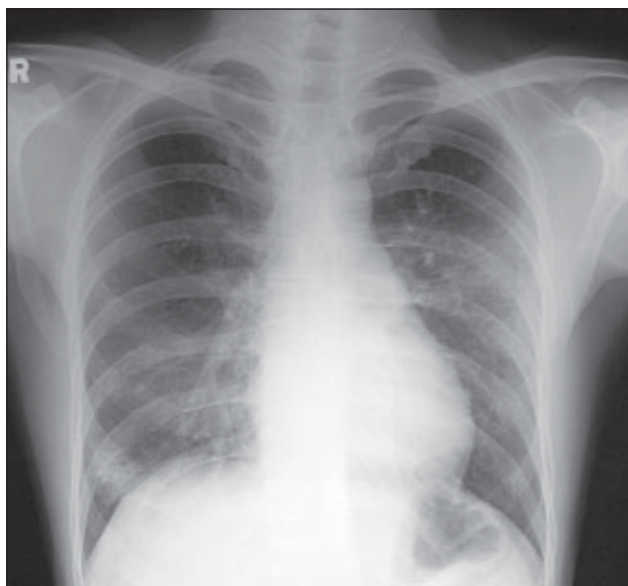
Chest X-ray on day 27 showed gradual resolution of bilateral lung infiltrates
